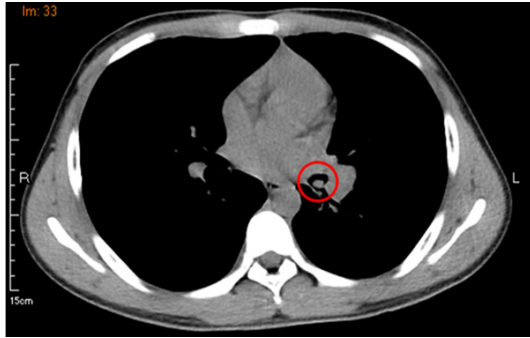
The CT revealed an endobronchial mass (red circle) obstructing the main bronchus of the left lower lobe.
